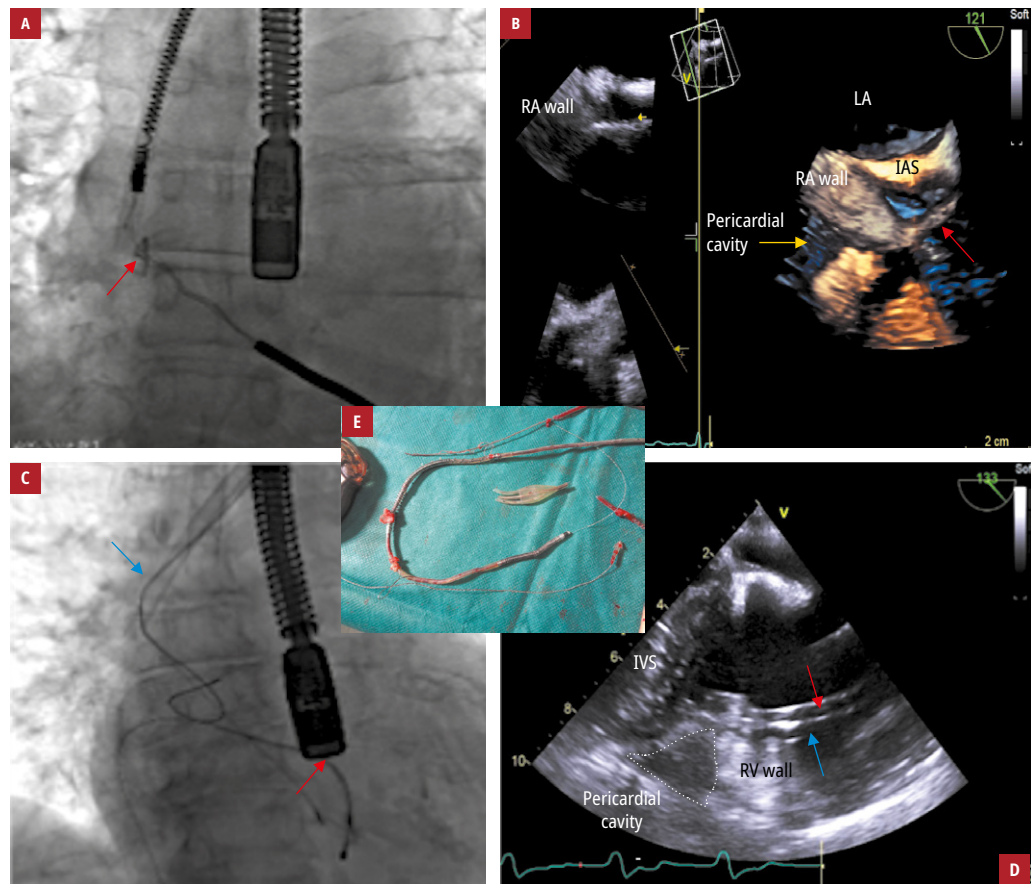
Monitoring of the process of pulling on the cardiac walls during lead dissection: A – fluoroscopy showing the extraction of a high-voltage lead, adhesion of the externalized coil to the right atrium wall (arrow); B – transesophageal echocardiography (3-dimensional, bicaval view) showing strong pulling on the right wall at the site of coil externalization and adhesion (red arrow), pseudo-cardiac tamponade (yellow arrow) due to separation of pericardial layers; C – ventricular lead extraction (red arrow) and the telescoping sheaths (blue arrow); D – transesophageal echocardiography (2-dimensional, midesophageal modified view) showing pulling on the wall of the right ventricle at the binding site, pseudo-cardiac tamponade (grey line)—pericardial separation due to ventricular wall traction. The uncoiled conductor (red arrow) is in the lumen of the sheath (blue arrow). E – the removed leads
